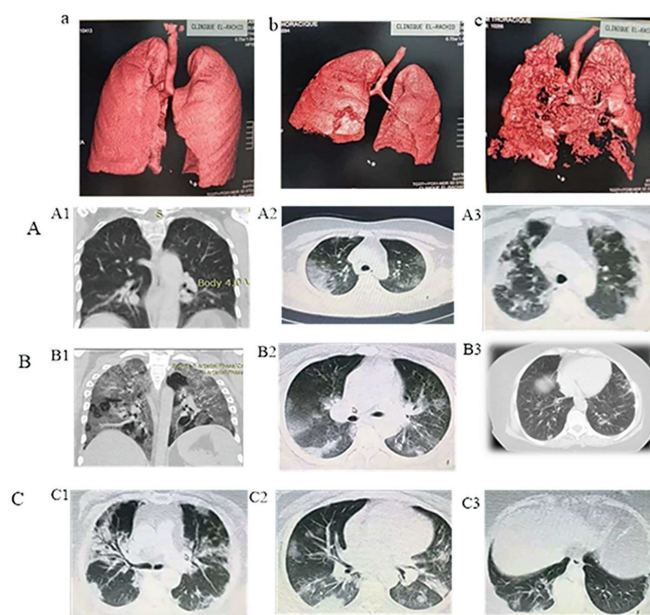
The chest CT images of infected patients with COVID-19 during their hospitalization. A: healthy patient. B: blood pressure patients. C: diabetes patient. A) Healthy patients and their ages range from 28 to 50 with mild to severe injury. B) Patients with blood pressure with ages range from 35 to 70 with mild to severe injury. C) Patients with diabetes, ages ranging from 40 to 75, with severe injury.
